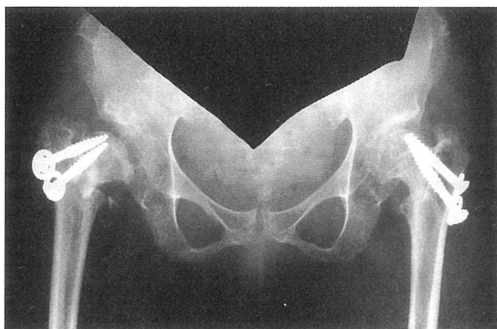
Post-operative radiograph at 14 years of age.
